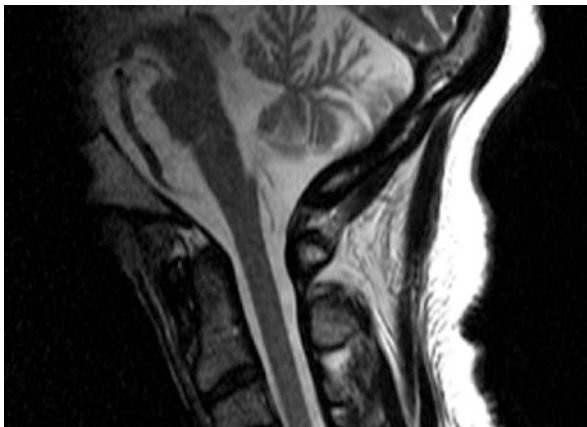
T2 weighted sagittal MRI showing a striking atrophy of the cerebellum and the pons
